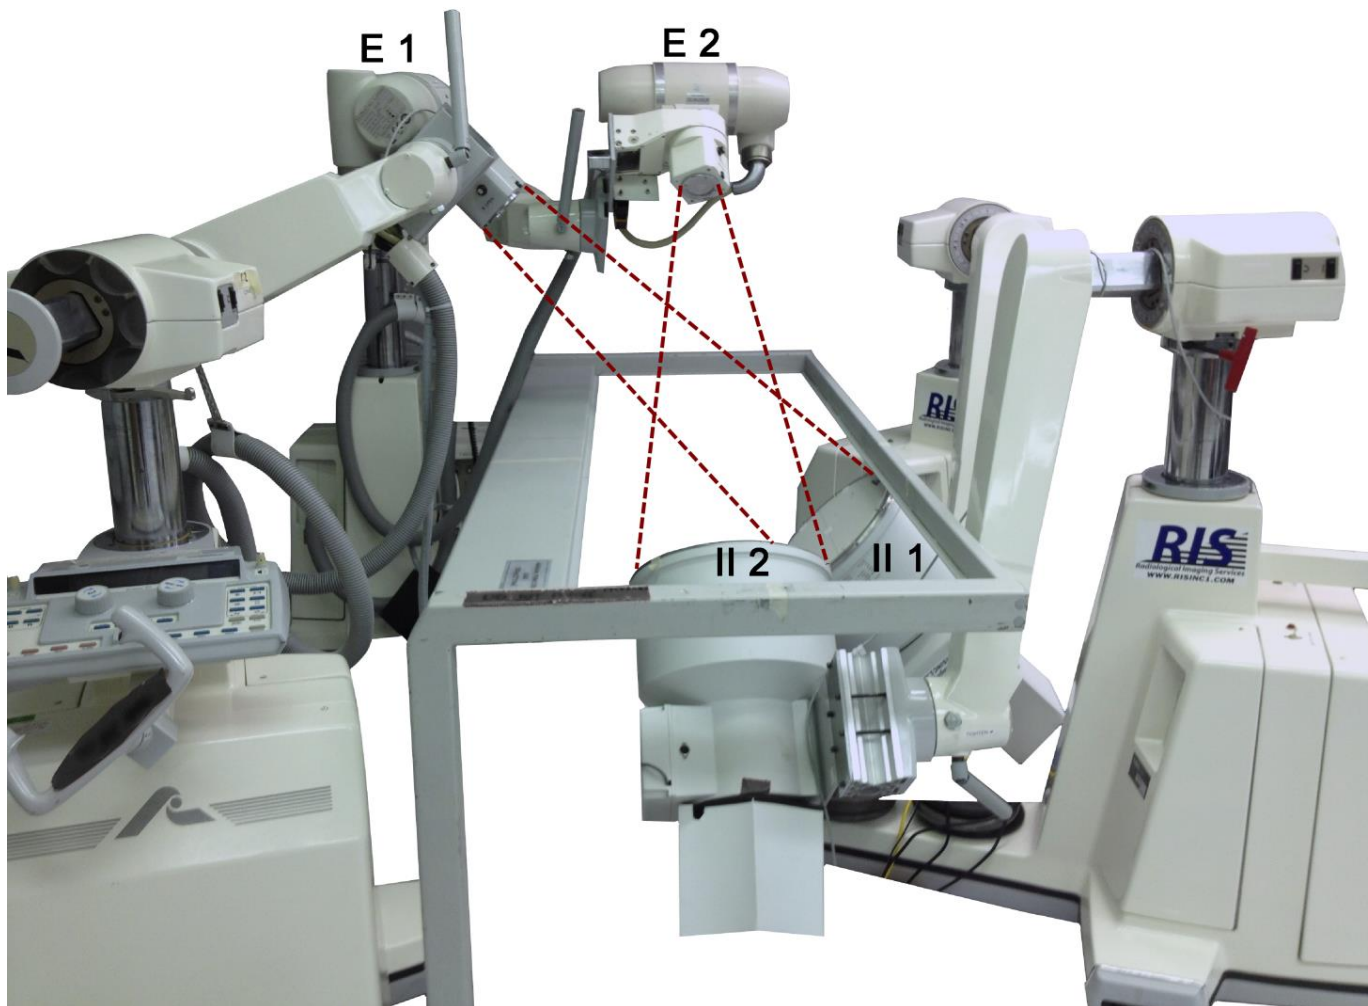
Dual fluoroscopy system configured to image the left hip during supine clinical exams. Dashed lines represent x-ray beam. E = emitter, II= image intensifier.
